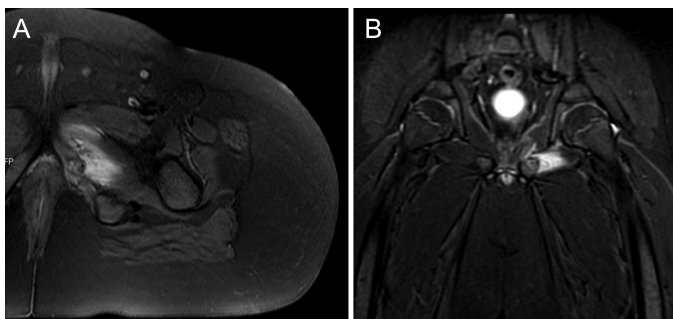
(A, B) Axial and coronal T2-weighted magnetic resonance images of the contralateral side of osteomyelitis. Soft tissue edema at the adjacent muscles to left ischiopubic synchondrosis. Imaging findings are similar to Figure 1A, B.
